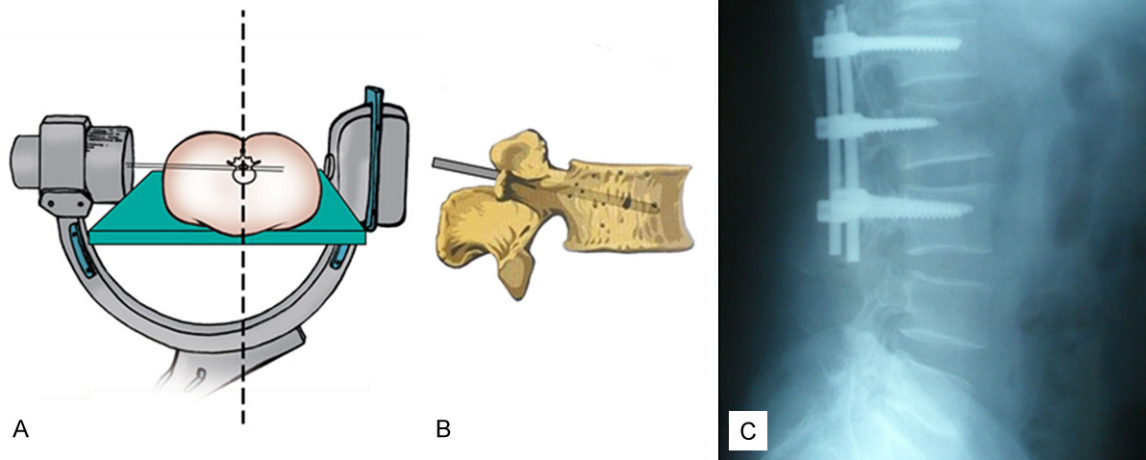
Anteroposterior radiographs exhibited improperly positioned screws (right). A. The projection of AP views. B. The cortical perforation or out of pedicle (right) should be judged based on the experience of surgeons.
